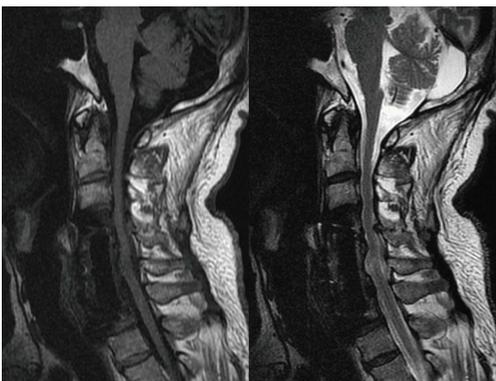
The follow-up sagittal T1- and T2-weighted magnetic resonance imaging demonstrated good implant position and no evidence of recurrent infection.
